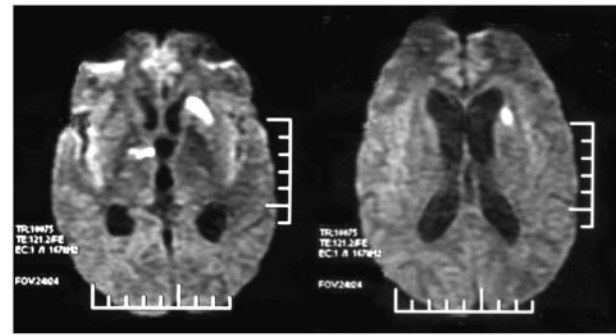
Cranial DWI MRI axial section showing acute infarct in the tubercular zone in a 9-year-old boy with stage II TBM. This patient did not have hyponatremia.
